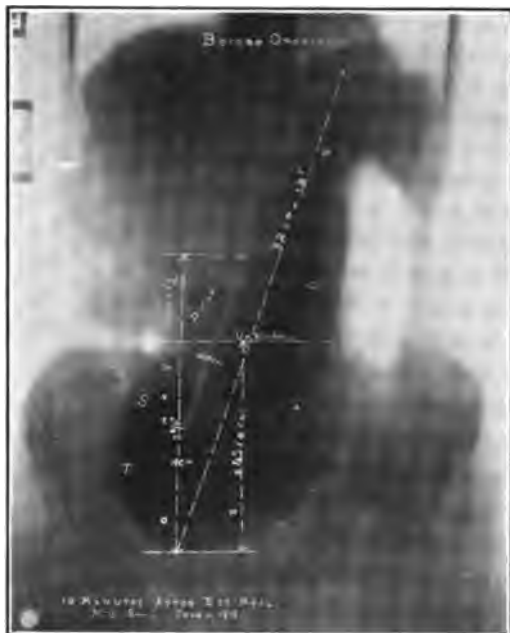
WATER-TRAP STOMACH, BEFORE OPERATION. Female aged 45. "Stomach trouble" for 18 years. Had given up all hope of being cured. Roentgen examination negative for ulcer, but showed definite water-trap stomach with large 6 hr. residue.
